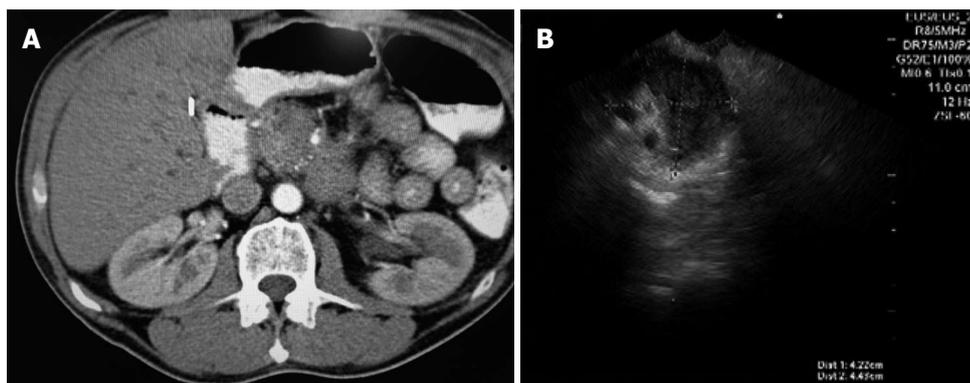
Pseudotumoral chronic pancreatitis in included patient. A: Computed tomography image; B: Endoscopic ultrasound image.
